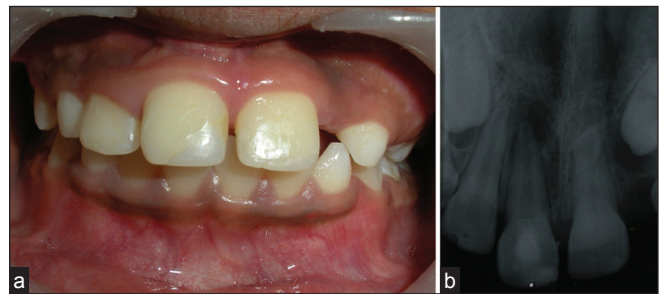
18 months follow-up: (a) Intra-oral view and (b) intra-oral periapical radiograph showing root-end closure
